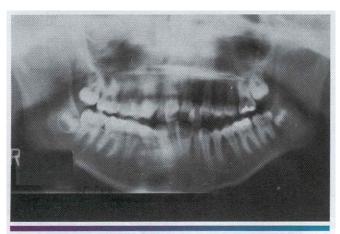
• Hemihyperplasia. Radiograph of the same patient in Figures 1-77 and 1-78. Mandible and teeth on the right side are enlarged. (Courtesy of Dr. George Blozis.)
